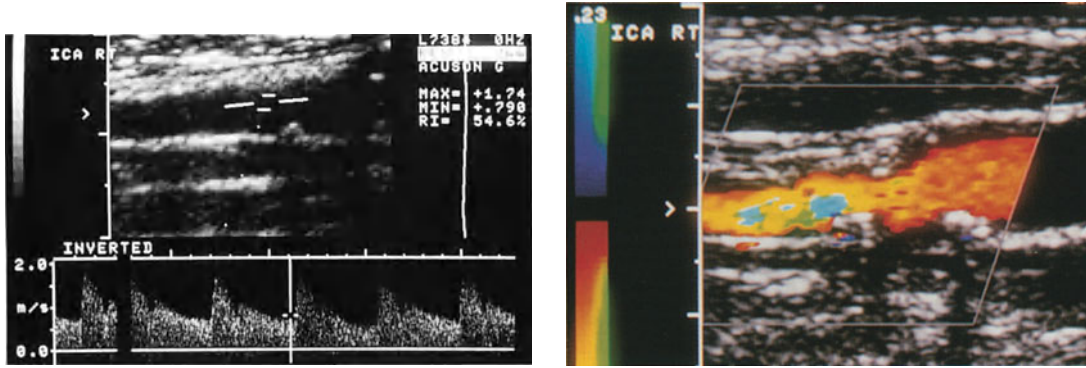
(left) Duplex Doppler sonography spectral tracing obtained at the level of the carotid bifurcation and proximal ICA shows broad bandwidth with a partially "filled in" systolic envelope (spectral broadening) representing turbulent flow
